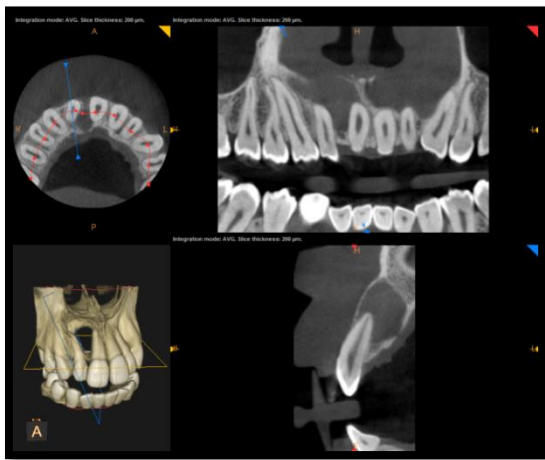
CBCT images showing exact location and extent of the lesion.
